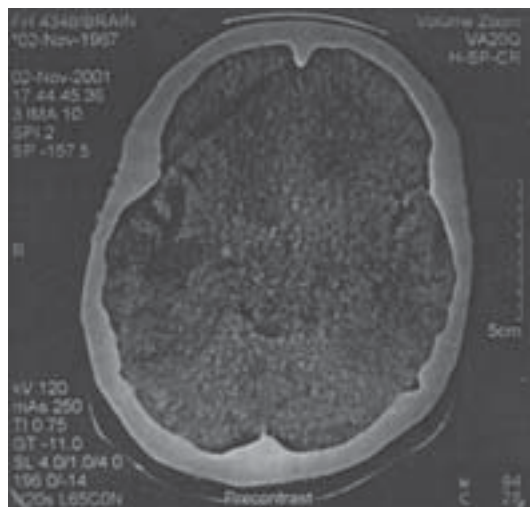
Plain CT scan of the brain revealed a finger-like low attenuation involving the white matter of the right temporal lobe.
